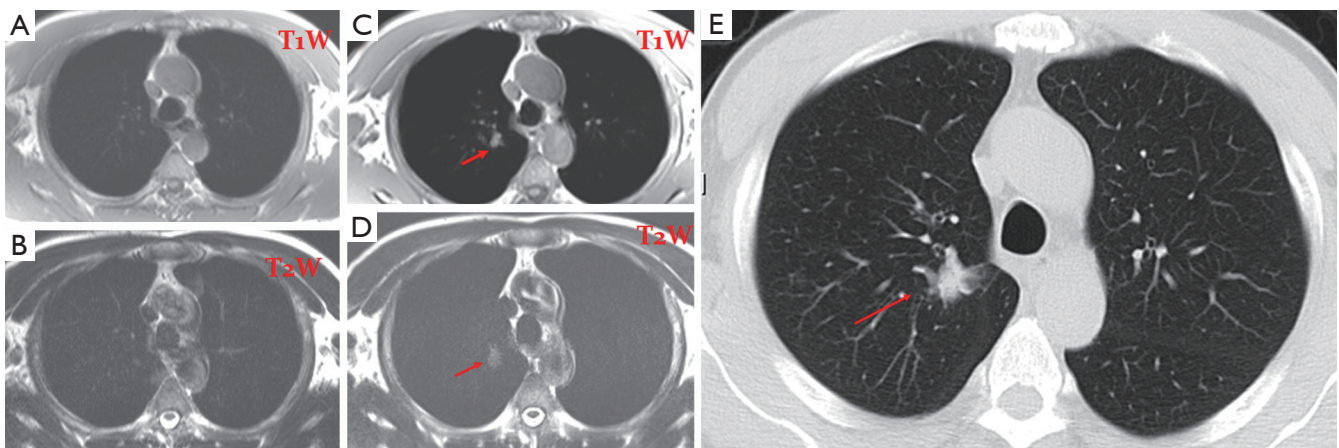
A 72-year-old male. (A,B) T1 & T2 weighted MR screening of the chest; no abnormality was detected in 2005; (C,D) T1 & T2 weighted MR screening of the chest shows a nodule (arrow) in 2008. It was also shown by CT (E) and confirmed to be a bronchioalveolar carcinoma (stage I) by surgery.
